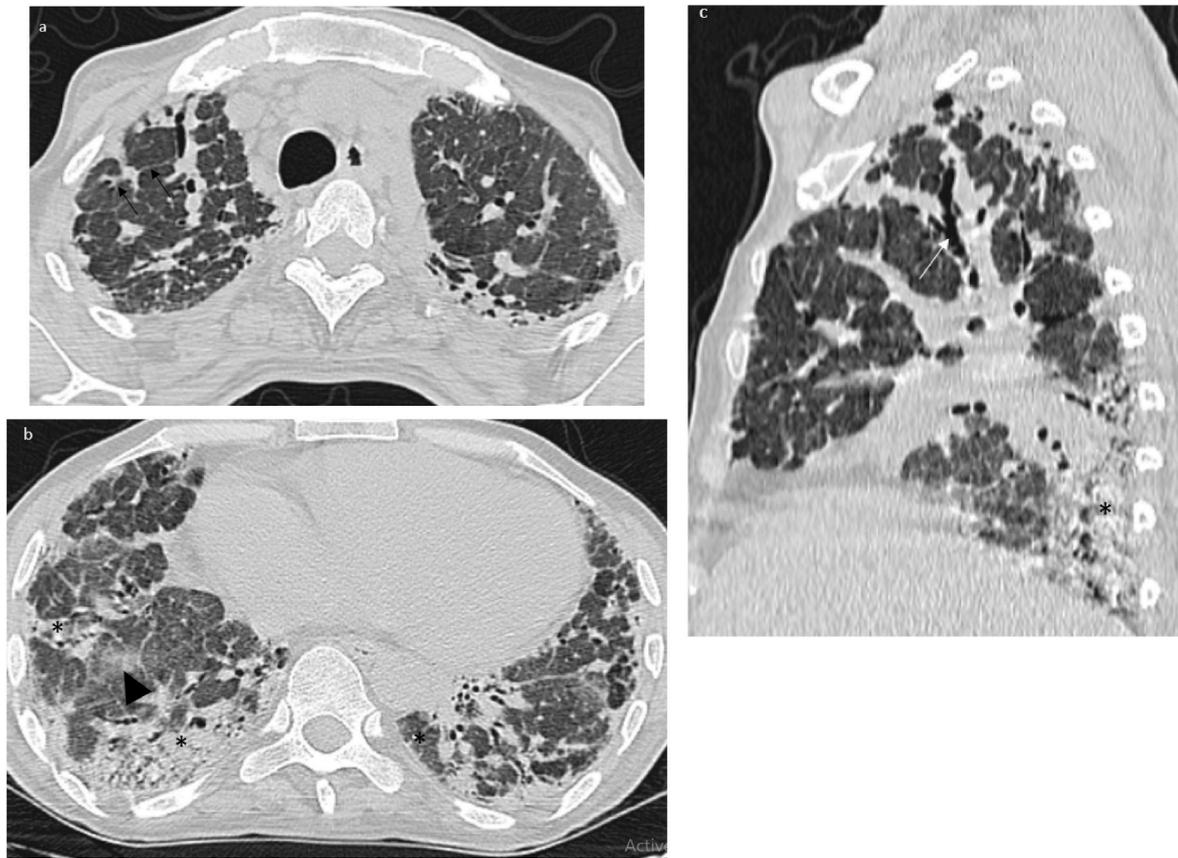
A 40-year-old-man 7 months follow-up non-enhanced chest CT axial (a,b) and sagittal images (c) showing residual, extensive multi-focal, bilateral, patchy dominant consolidations (*), some ground glass opacities (Black arrow head), alongside bronchiectasis (White arrow), and interlobular septal thickening (Black arrow).
